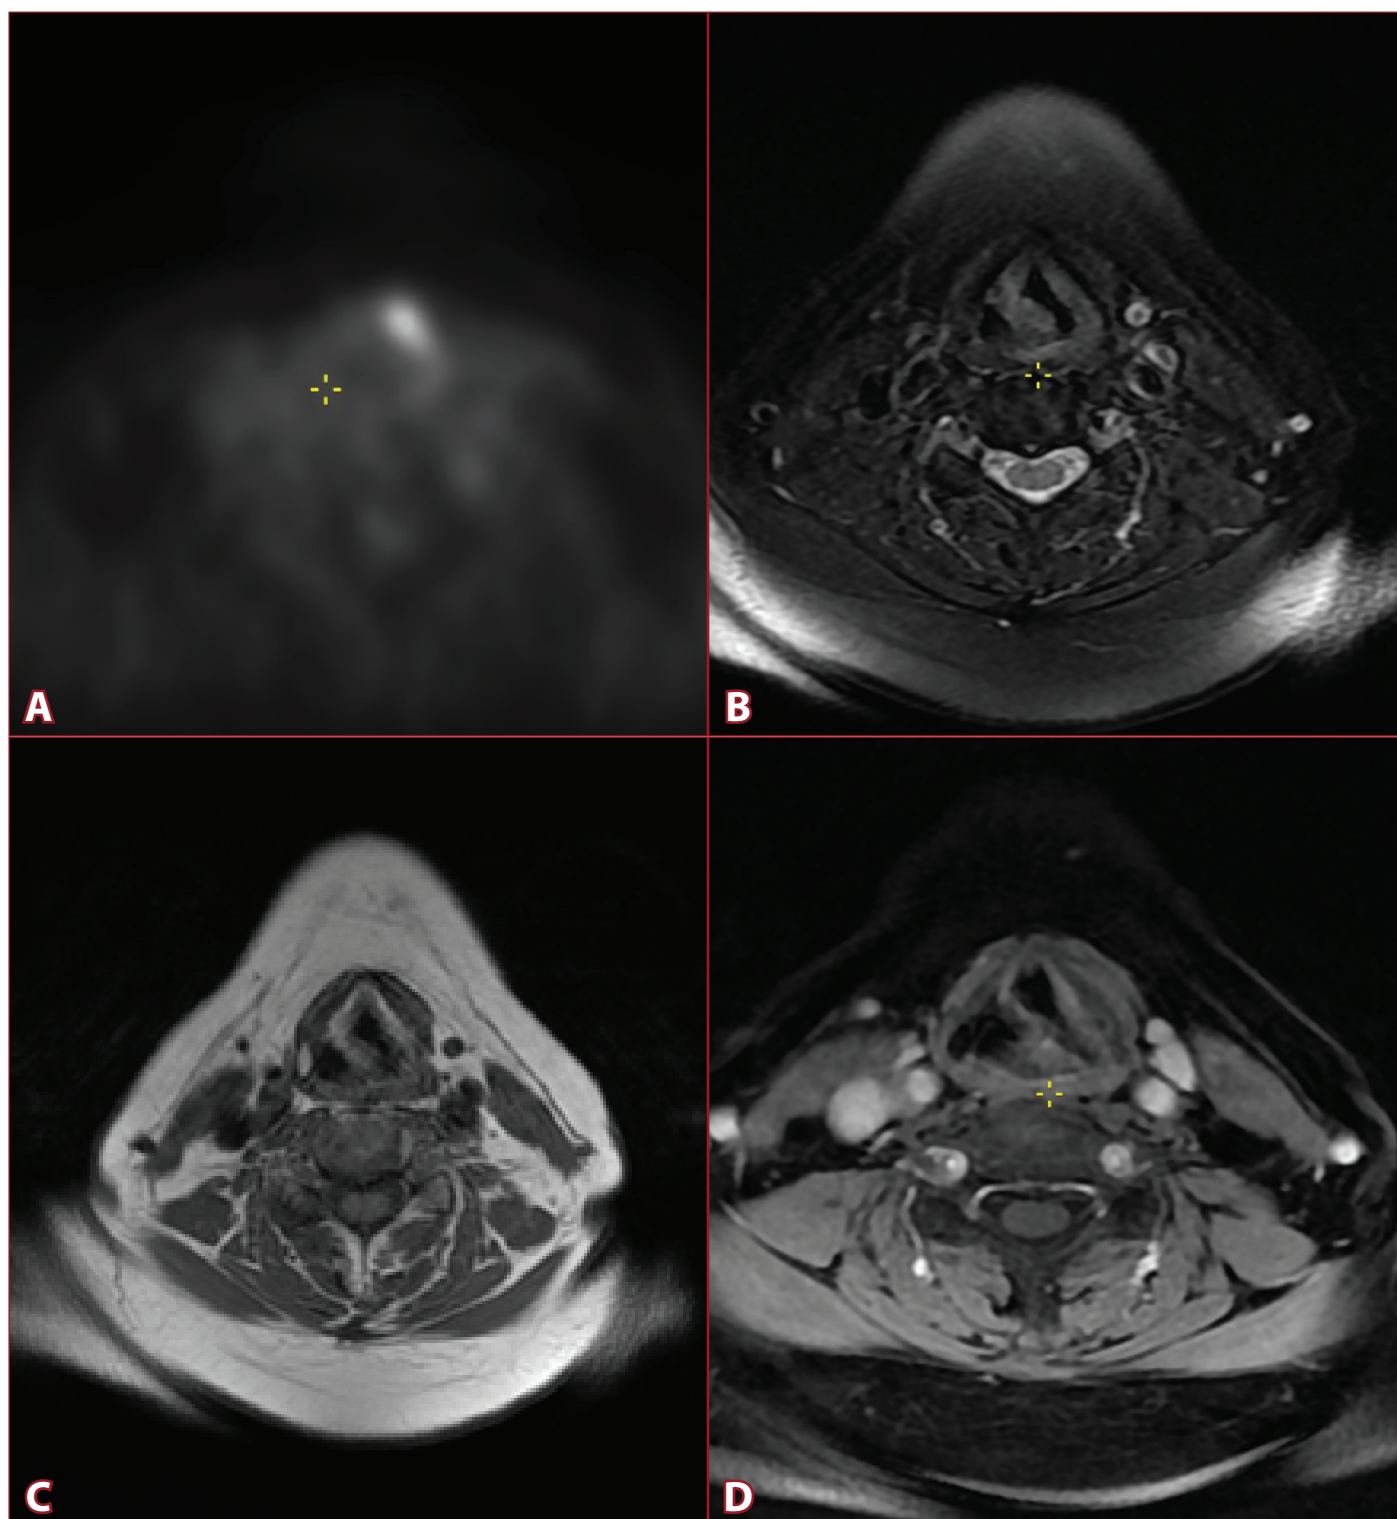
A 66-year-old patient followed for breast cancer showed uptake at the level of the left vocal cord on PET imaging. (A) PET image demonstrates focal FDG uptake at the vocal cord level. (B-C) Axial T1-weighted and fat-suppressed T2-weighted images demonstrated medialization of the right vocal cord, thickening of the aryepiglottic fold, and dilatation of the piriform sinus; these findings were interpreted as consistent with right vocal cord paralysis. (D) Axial fat-suppressed post-contrast T1-weighted image showed no evident contrast enhancement.
